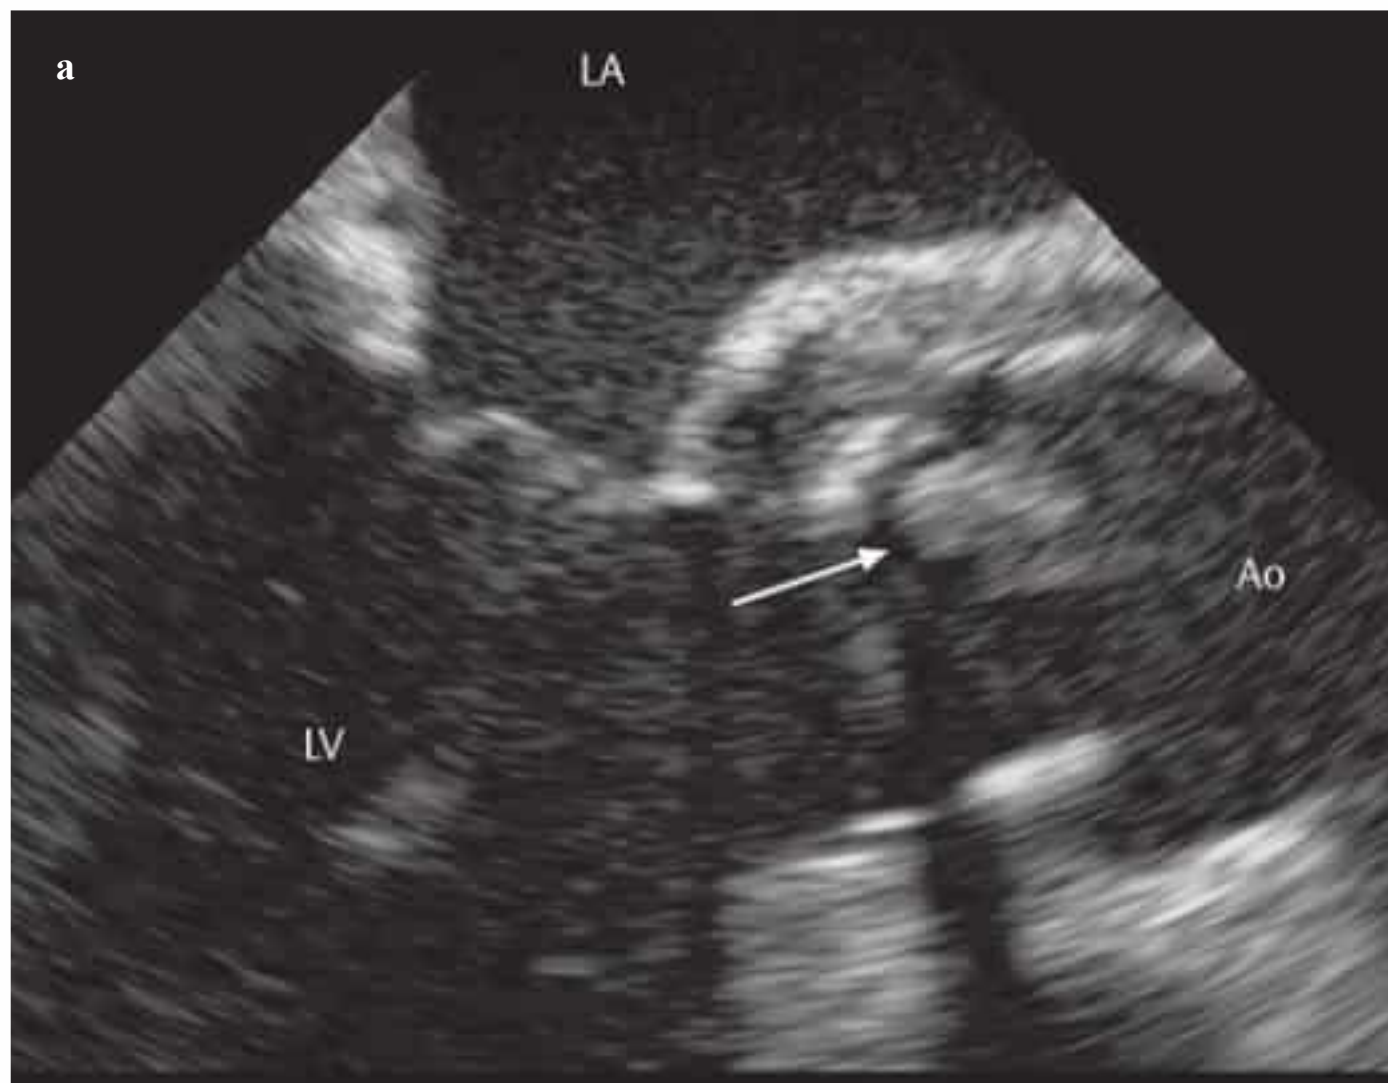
a–d Echocardiography of endocarditis following valve replacement or reconstruction.
